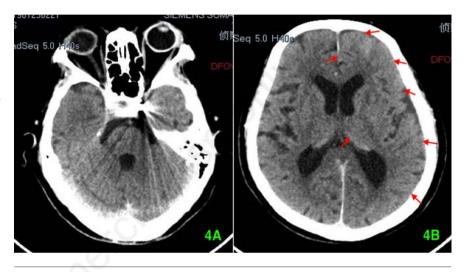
A-B) None contrast post-operative computed tomographic scan images showing cortical contrast enhancement in the vascular territory of the left internal carotid artery as well as edema. No intracranial hemorrhage, air embolism as well as cerebral infarction were observed. Red arrows show the demarcations or margins and the extent of contrast-induced encephalopathy.
